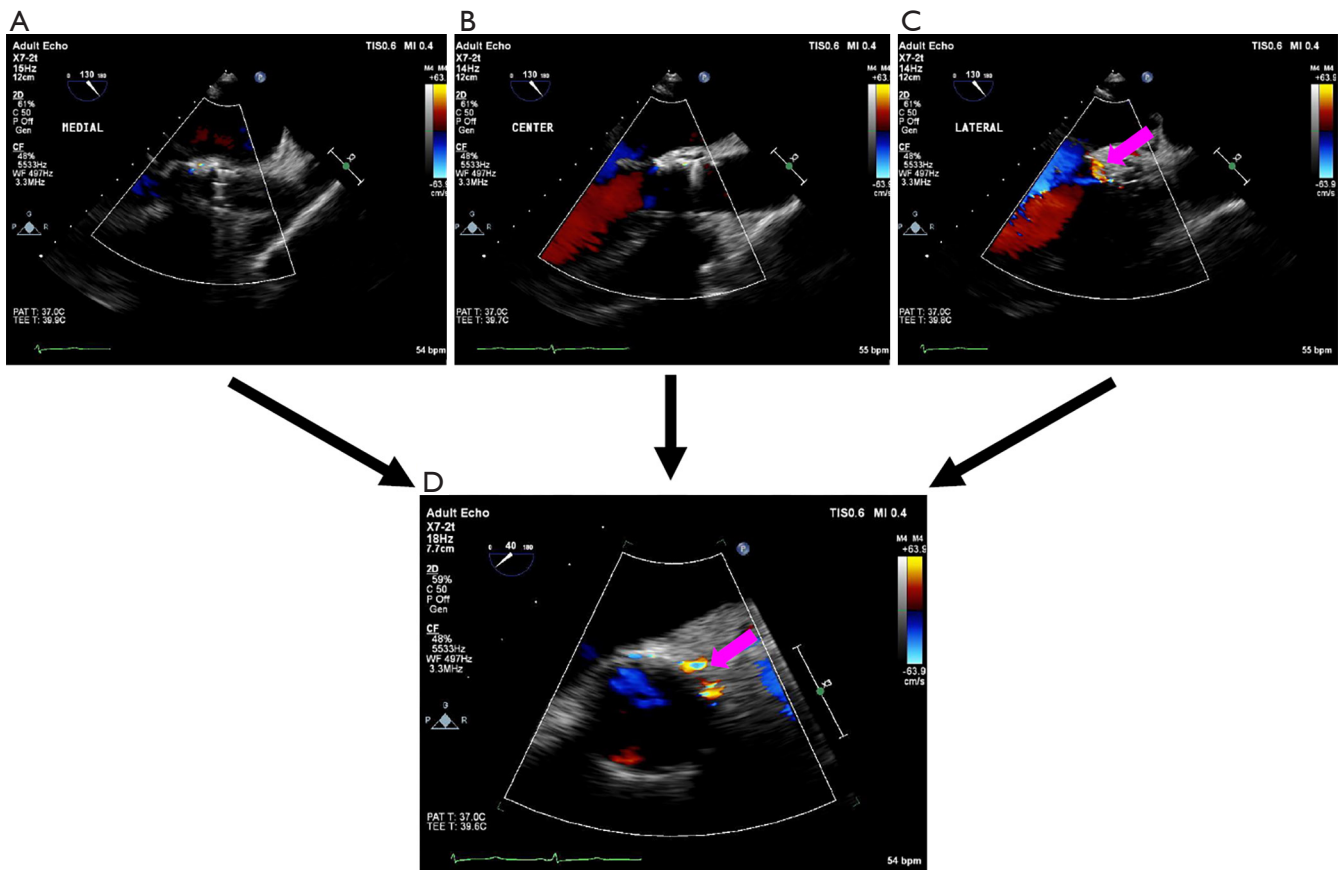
Detection of paravalvular aortic regurgitation (AR) after transcatheter heart valve (THV) deployment. Transesophageal echocardiography (TEE) can detect the true orifice of paravalvular AR (pink arrow) to prevent overestimation of AR severity using the long-axis view by rotating a TEE probe from the medial (A), to the center (B) to the lateral (C) side, and the short-axis view at the level of the aortic annulus (D).
